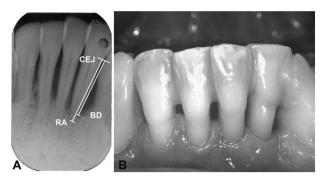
(A) Measurement of relative bone loss. CEJ: cemento-enamel junction; BD: radiographic bottom of the bony defect; RA: radiographic dental apex. (B) Clinical situation of the same patient after 15 years of supportive periodontal therapy.
